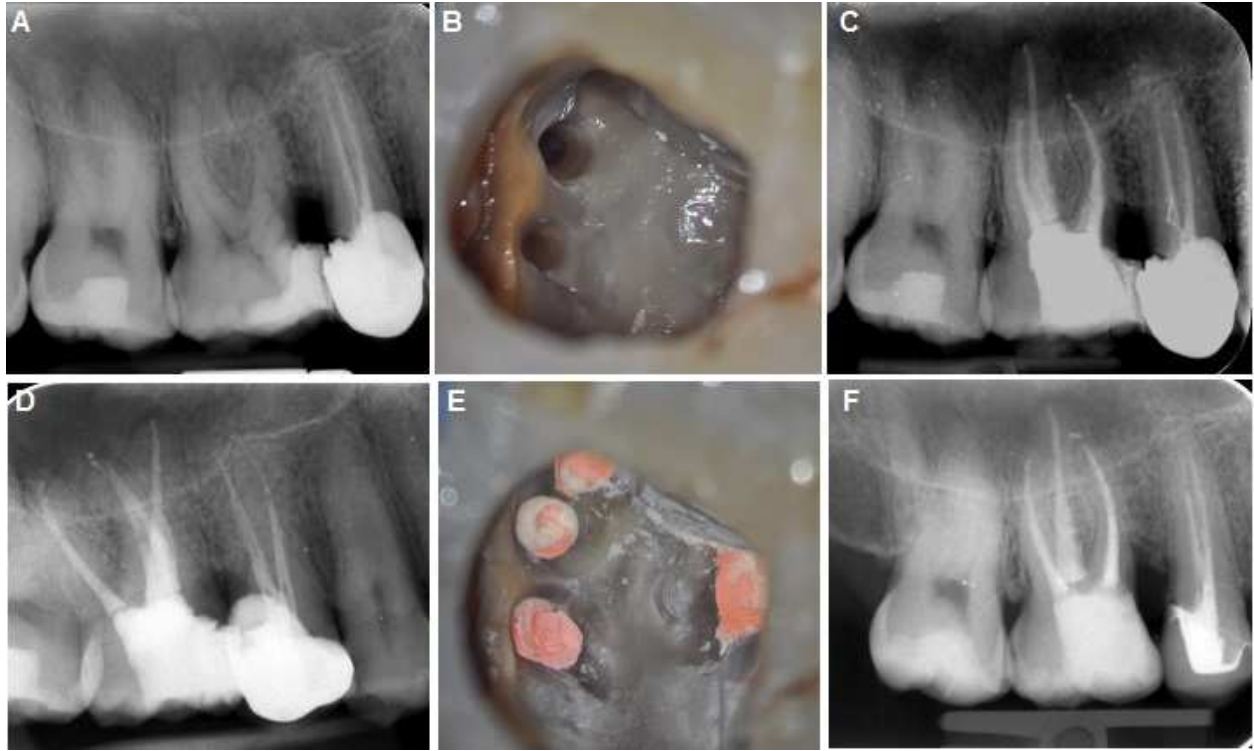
(A) A preoperative radiograph of the right maxillary first molar. (B) An occlusal view showing three root canal orifices in the MBR. (C and D) Postoperative radiographs. (E) Occlusal view showing obturation of the mesiobuccal canals. (F) One-year recall radiograph.
